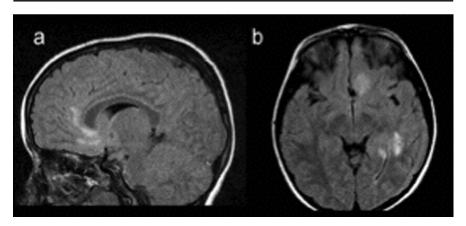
MRI investigation follow-up after 3 months. (a) Significant increase of the left frontal lobe lesions (sagittal FLAIR). (b) New lesions in posterior temporal lobe, involving the periventricular white matter (axial FLAIR).
